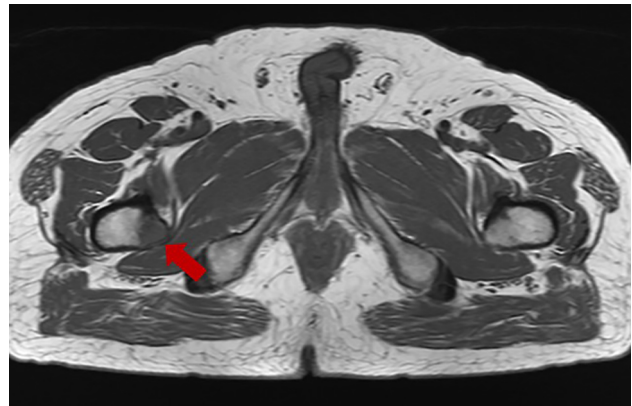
T1-weighted magnetic resonance imaging showing low signal intensity at the lesser trochanter.
